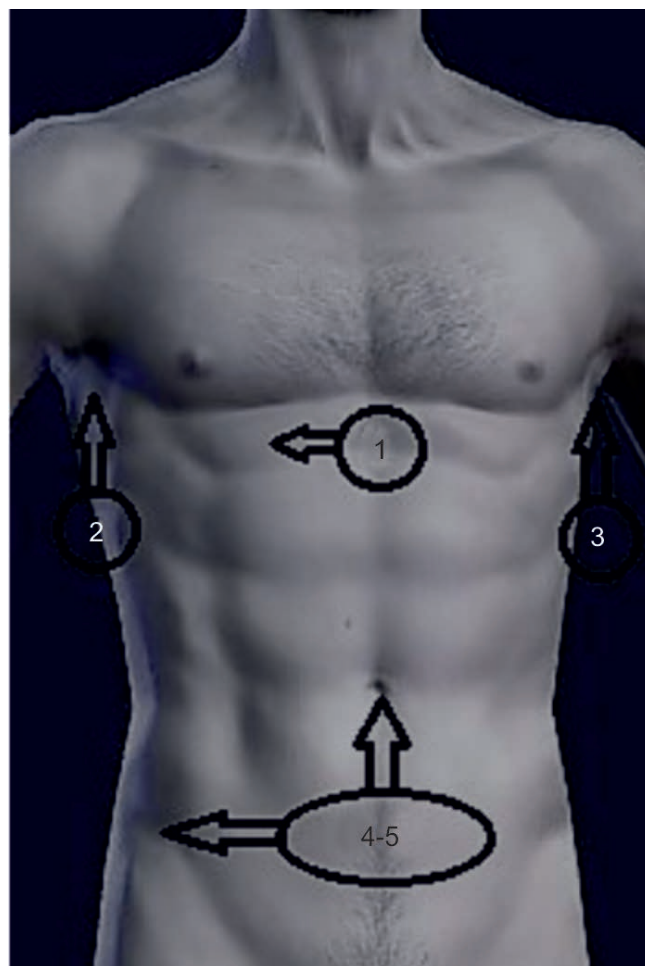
Locations of ultrasound transducer application during F.A.S.T. examination
